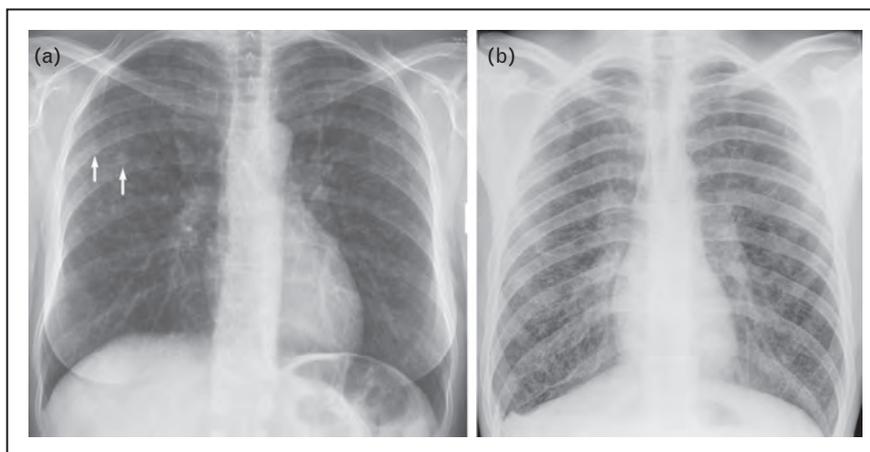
Chest radiographs in two patients with Langerhans' cell histiocytosis. (a) There is symmetrical abnormality with multiple nodules in the mid/upper zones and relative sparing of the lower zones; two nodules in the right lung are cavitating (arrows). (b) A diffuse reticular pattern in both lungs – there is no apparent sparing of the lung bases but note that despite extensive reticulation, the lung volumes are increased.
